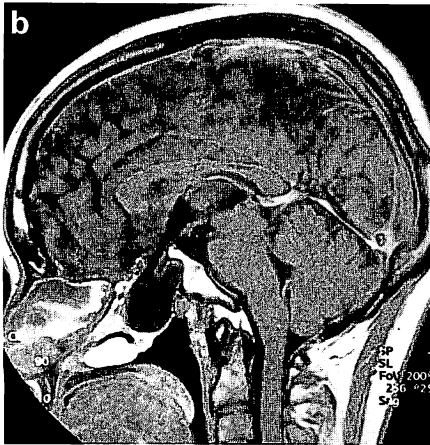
Reconstructed coronal image of X-ray computed tomography (a) shows a bony defect at the floor of the enlarged pituitary fossa. Magnetic resonance imaging (b, enhanced T₁-weighted sagittal image; c, T₂-weighted coronal image) showing the third ventricle herniating downward into the cystic mass with cerebrospinal fluid intensity in the epipharynx. Right internal carotid angiograms (d, frontal view; e, lateral view) and left internal carotid angiograms (f, frontal view; g, lateral view) showing the occlusion of bilateral internal carotid arteries immediately distal to the origins of the posterior communicating arteries as well as development of moyamoya vessels (arrows).
